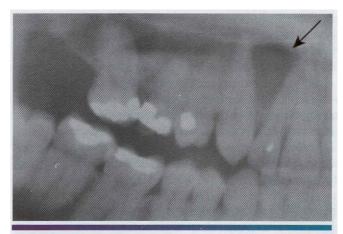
• "Globulomaxillary cyst." Inverted pear-shaped radiolucency (arrow) between the maxillary right cuspid and the lateral incisor. Biopsy revealed a periapical cyst.
